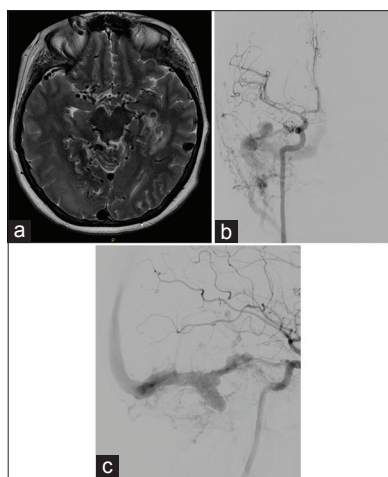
(a) Magnetic resonance imaging (T2-weighted). Three-month preembolization showing venous congestion and occlusion. (b) Angiogram. Preembolization image demonstrating early venous filling and a high flow dural arteriovenous fistula involving the transverse sinus. (c) Angiogram (lateral). Preembolization image demonstrating early venous filling and a high flow dural arteriovenous fistula involving the transverse sinus
